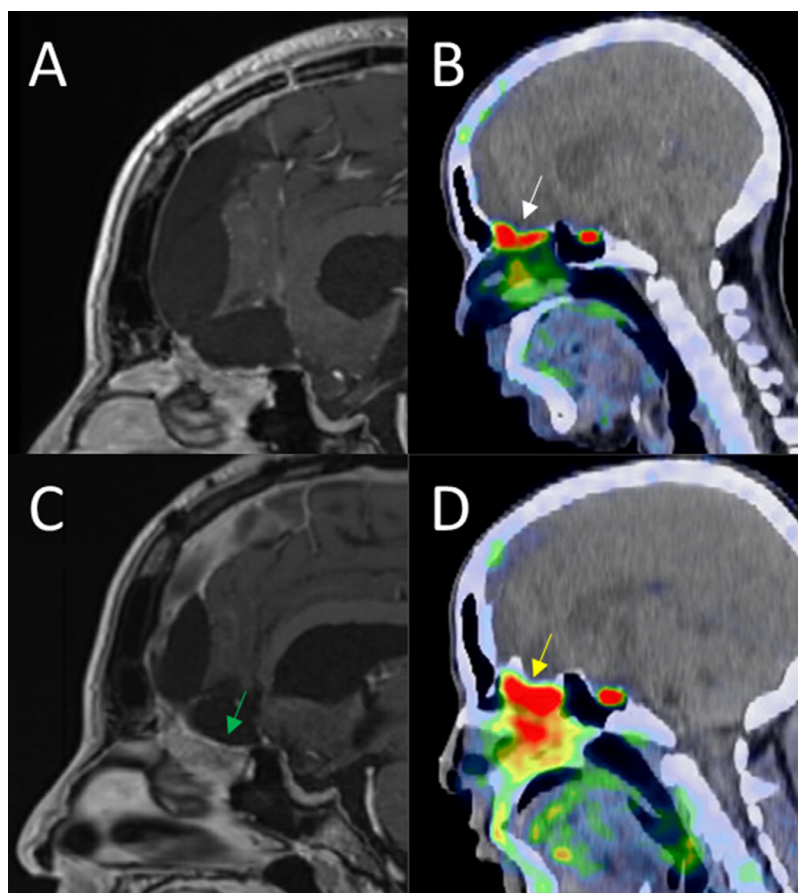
Postoperative magnetic resonance imaging (A) suggested a gross total resection with contrast enhancing reactive changes only, but positron emission tomography (PET) imaging (B) showed focal uptake along the cribriform plate (standardized uptake value 7.43, white arrow) suspicious for residual disease. The patient declined to pursue recommended adjuvant radiation therapy. Two years later, surveillance magnetic resonance imaging (C) showed increased soft tissue signal (green arrow) in the area of the cribriform plate with prior focal PET uptake with continued avidity (standardized uptake value 8.96, yellow arrow) noted on repeat PET imaging (D).
